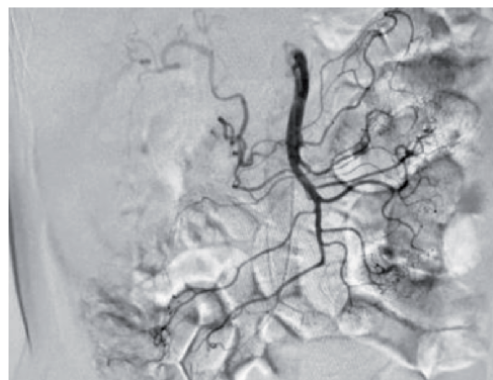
X-ray angiography of the inferior mesenteric artery (IMA) with contrast media. Its supplies arterial blood to organs of hindgut-distal 1/3 of the transverse, splenic flexure, descending colon, sigmoid, rectum.
